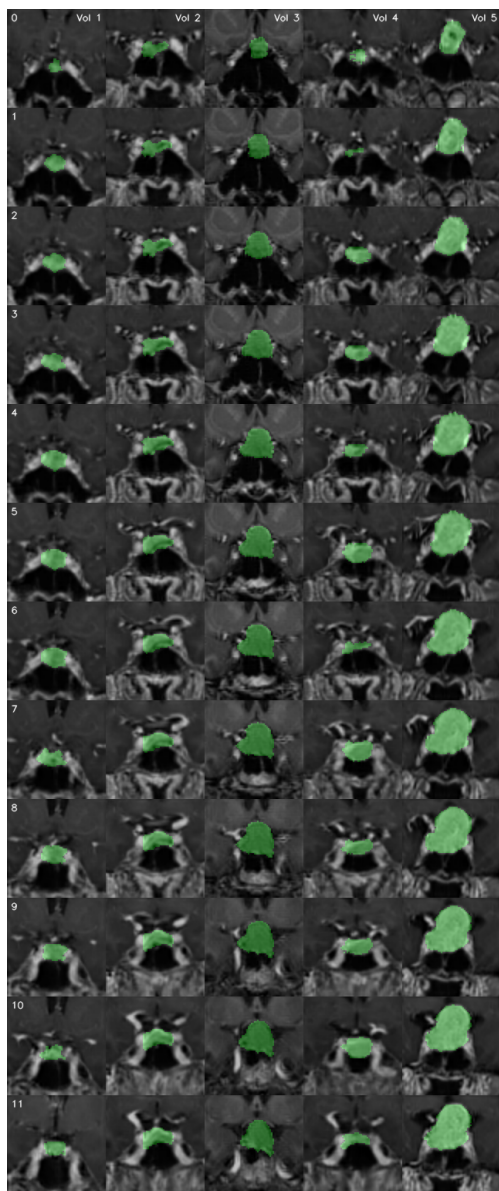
Generated annotations for the corresponding MRI slice are highlighted with a transparent green color. A grid visualizing slices of 5 generated MRI volumes. Each volume is in a separate column, while rows represent the slice index conditioning.
